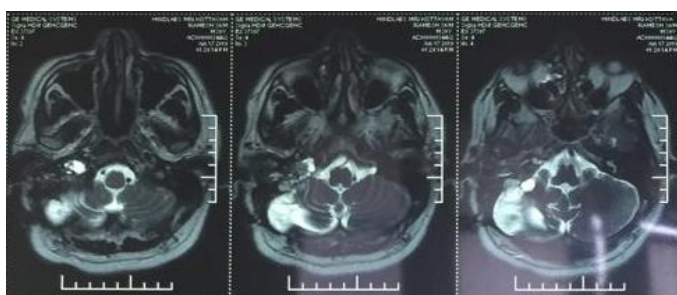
MRI Brain- Heterogenous T2 signal lesion with cystic and solid areas in right CP angle cistern, right mastoid and right jugular foramen.
